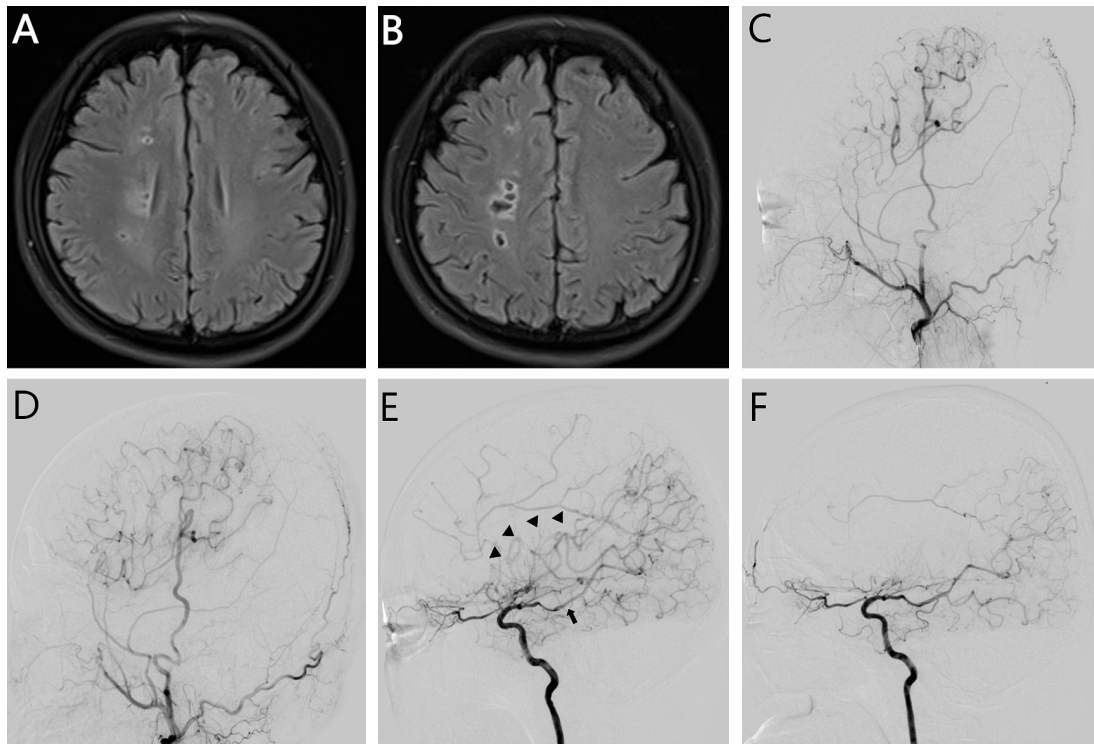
Preoperative and postoperative radiological findings of a 36-year-old woman. (A,B) Flare magnetic resonance imaging showing right frontal-parietal and periventricular infarction. (C,D) Postoperative angiography shows a right STA parietal branch bypass. Long-term angiography shows extensive collateral anastomosis between STA and cerebral cortex, regarded as Matsushima grade A. (E) Preoperative carotid angiography showed the formation of moyamoya vessels on the skull base (arrowheads), and anastomosis is formed between the posterior lateral choroidal artery (arrow) and pericallosal artery. (F) Long-term angiography showing the extensive disappearance of moyamoya vessels in the skull. STA, superficial temporal artery.
